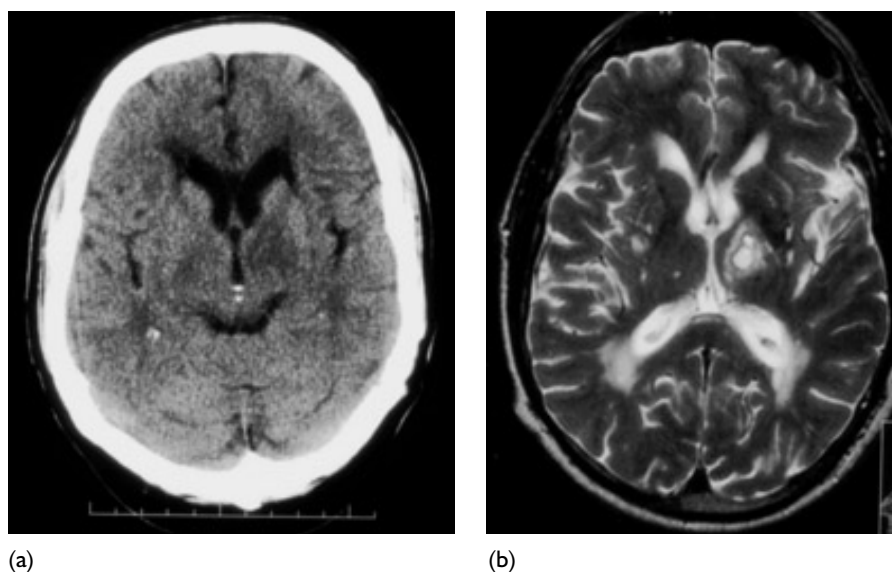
A 68-year-old man with right hemiparesis and dysphasia, with mild weakness persisting. (a) CT scan; (b) T2-weighted MR scan. Scans were taken at 11 days.
